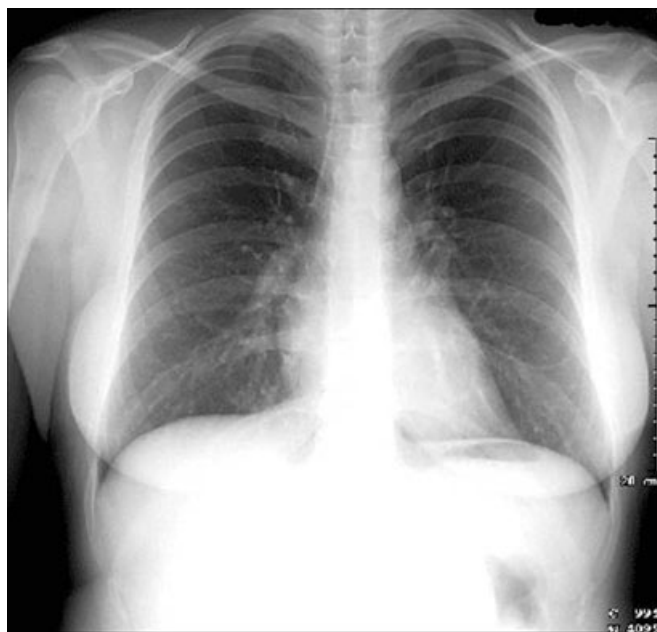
Chest radiograph of our patient.
